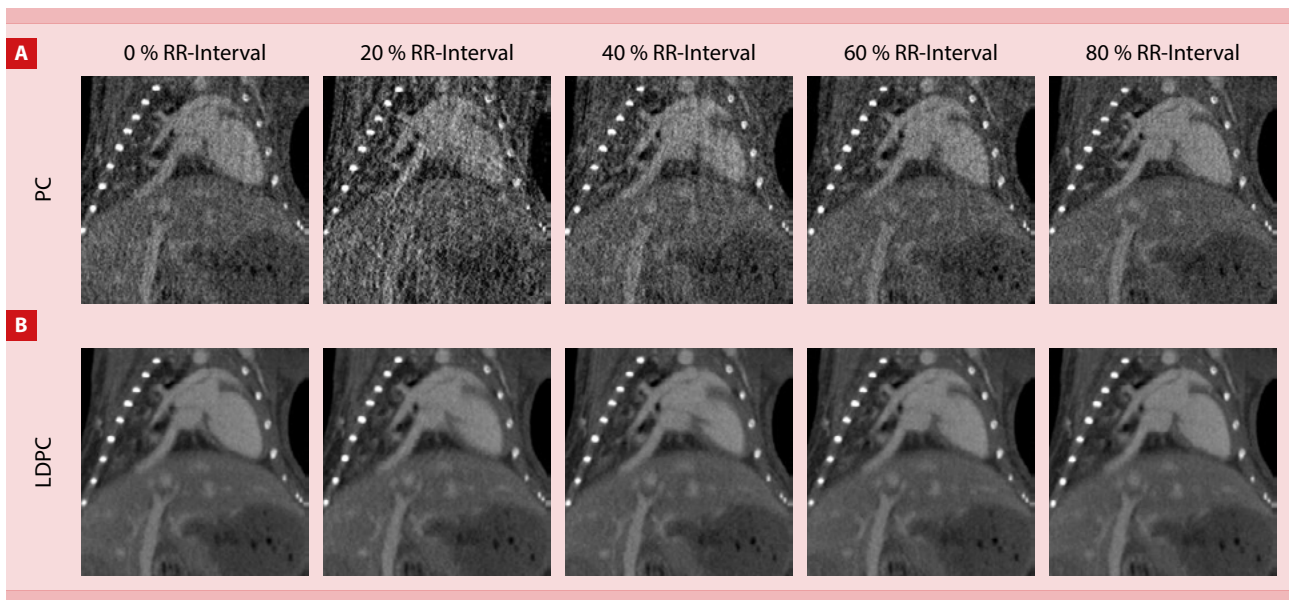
Coronal CT images at various time instants spaced equidistantly throughout the cardiac cycle acquired using the different reconstruction methods at a radiation dose of 250 mGy.
